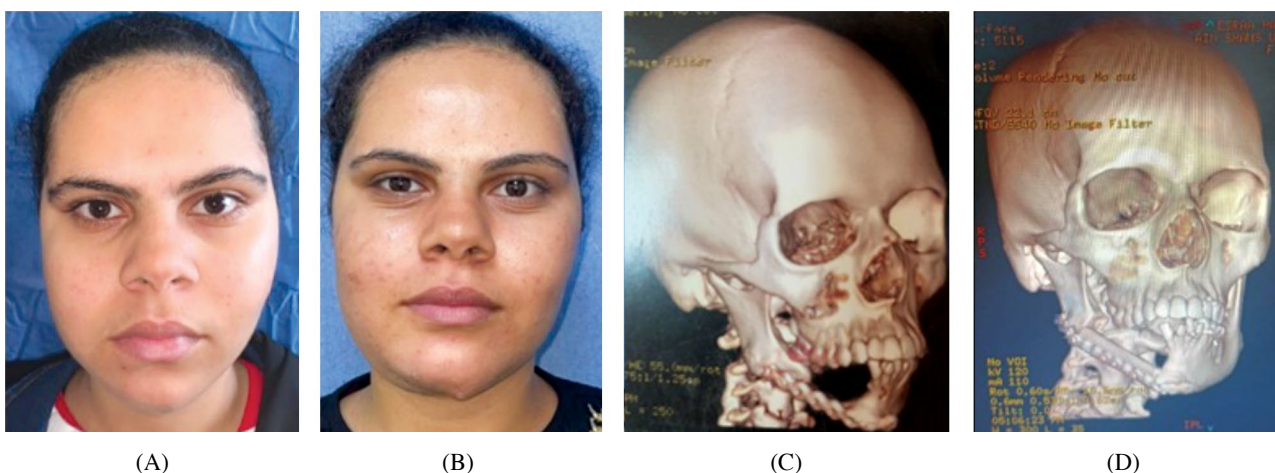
Case (3): (A): Pre-operative photo of the case, (B): Post-operative photo of the case, (C): Pre-operative CT showing a lateral mandibular defect, (D): Postoperative CT showing one bone segment of the fibula used to compensate the lateral defect without the need of the 3D models.
